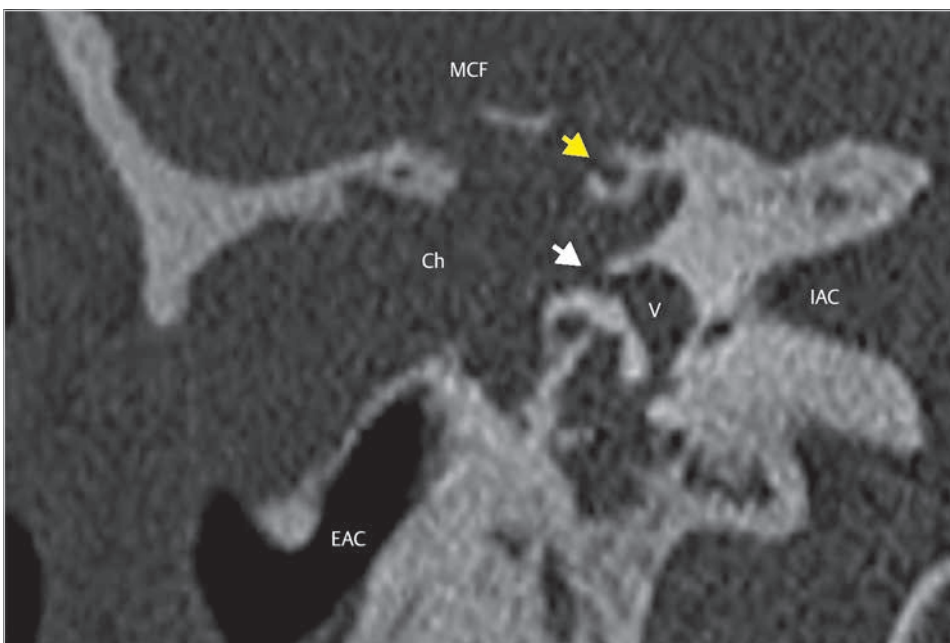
The coronal CT scan demonstrates soft tissue density filling the mastoid cavity eroding heavily the medial wall of the antrum. Large fistulae in both the superior (yellow arrow) and the lateral semicircular canals (white arrow) are identified. Ch, cholesteatoma; EAC, external auditory canal; IAC, internal auditory canal; MCF, middle cranial fossa; V, vestibule.
